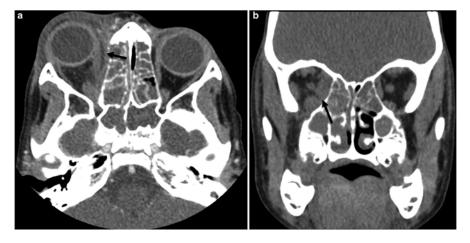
Orbital cellulitis. Contrast CT (a) axial (b) coronal. *Black arrow* demonstrating fat stranding and edema involving the medial and inferior recti muscle on the right with no abscess collection
